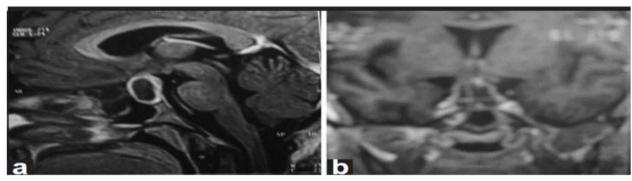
MRI features of Pituitary Abscess
